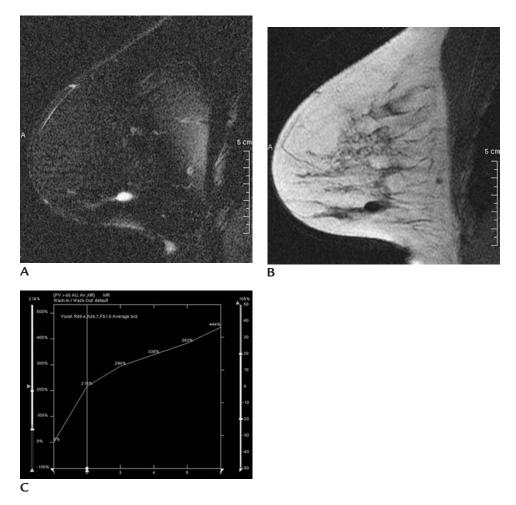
Fibroadenoma (myxoid/cellular). (A) Sagittal T2-weighted fat suppressed image. Oval mass characterized by bright signal inferiorly. (B) Sagittal T1-weighted image, same table top position as in (A). Low signal intensity for the mass seen on the T2-weighted image. (C) Slow initial phase and persistent type delayed curve characterizes lesion. This curve type is commonly seen with benign lesions.
